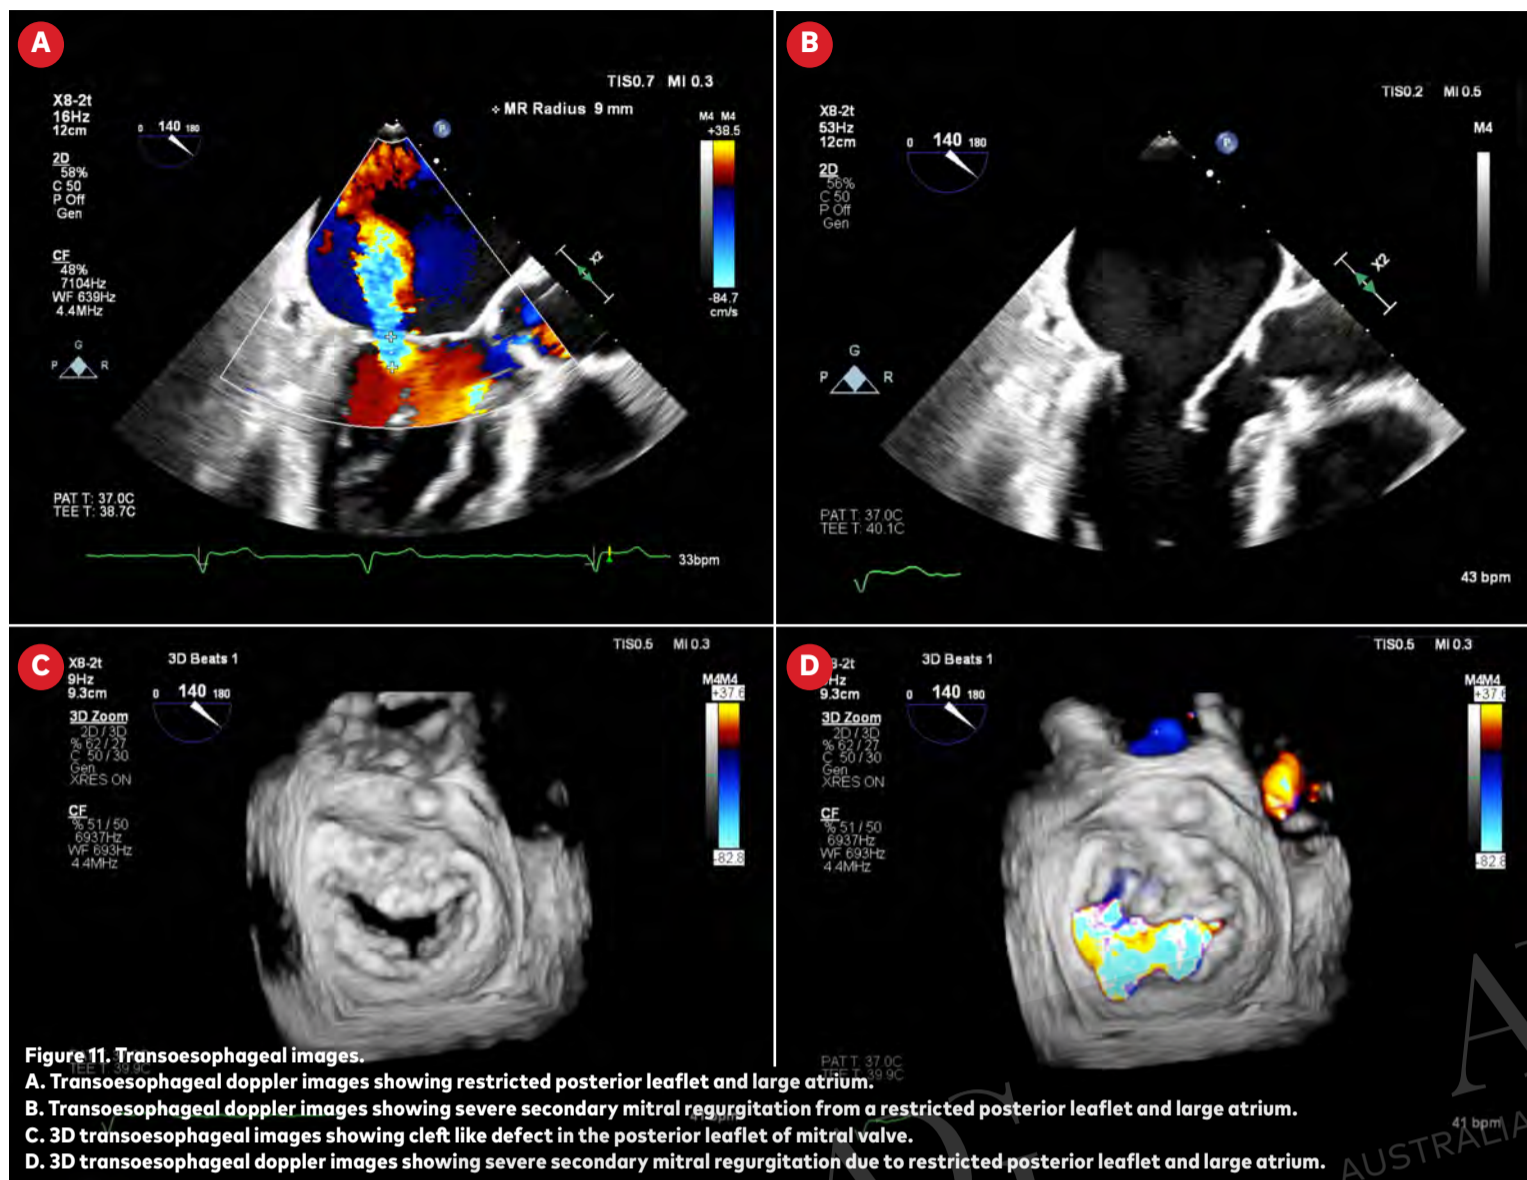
Transoesophageal images.
